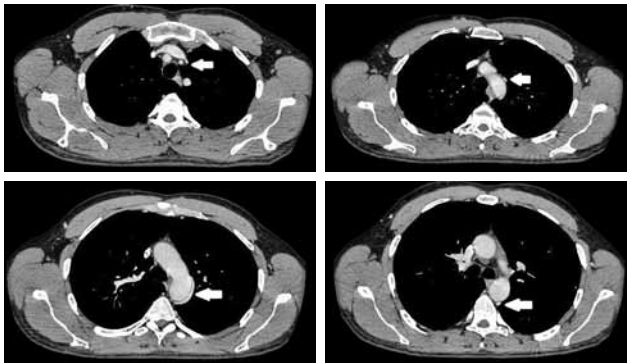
Computed tomography image showing a dilated left superior intercostal vein.
